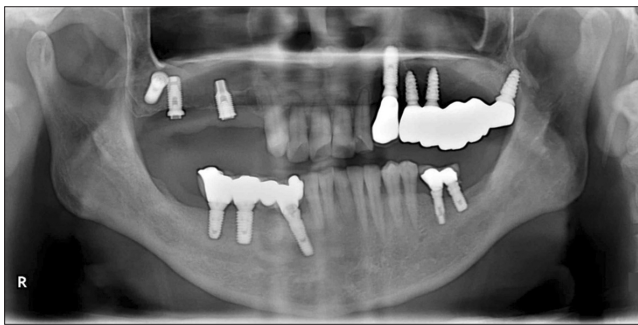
Preoperative panoramic radiograph. The implants in the maxillary right second premolar and second molar regions were affected with severe peri-implantitis, and the implant in the maxillary right first molar region exhibited osseointegration failure and was displaced into the maxillary sinus cavity.
